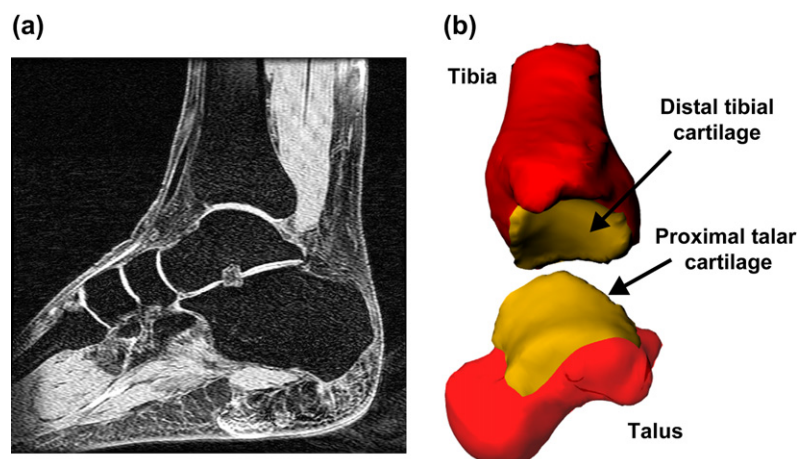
(a) A typical sagittal plane MR image of the talocrural joint; (b) 3D bony and cartilage model of the talocrural joint.
